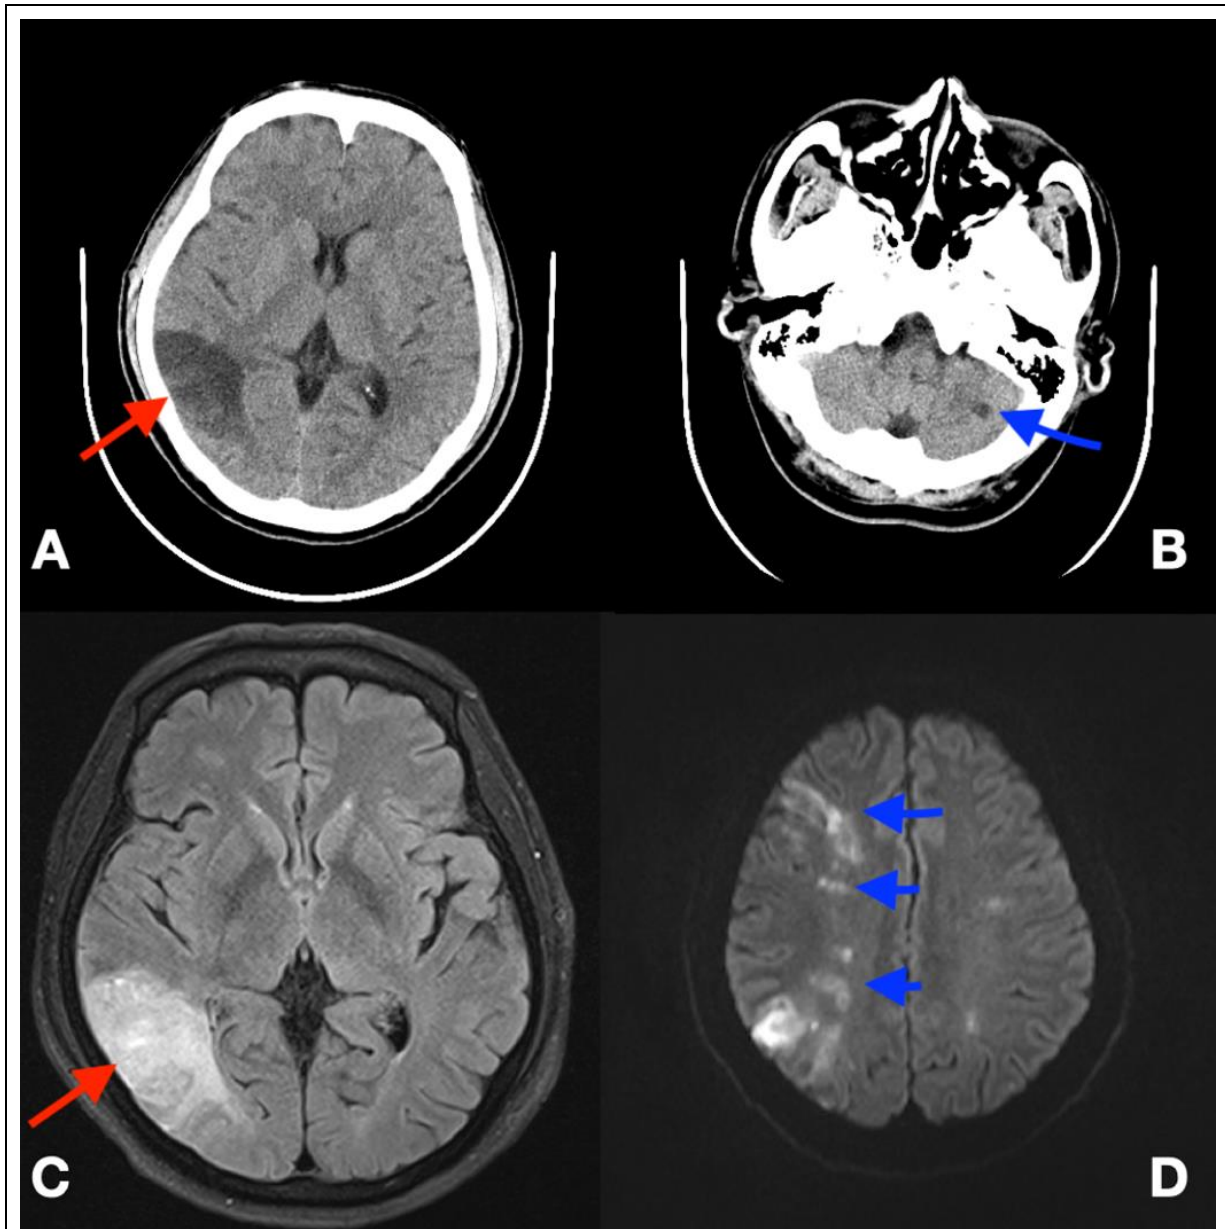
Brain imaging performed on day 1 of admission. Computed tomography of the brain axial views (A and B), showing infarct in the right posterior middle cerebral artery territory (red arrow in A); also, an old infarct in the left inferior cerebellar hemisphere (blue arrow in B). Magnetic resonance of the brain (C and D) showing acute to subacute infarct in the right posterior temporoparietal lobe (red arrow in C) and multiple subacute infarcts in the right frontoparietal area in watershed distribution (blue arrow in D).
